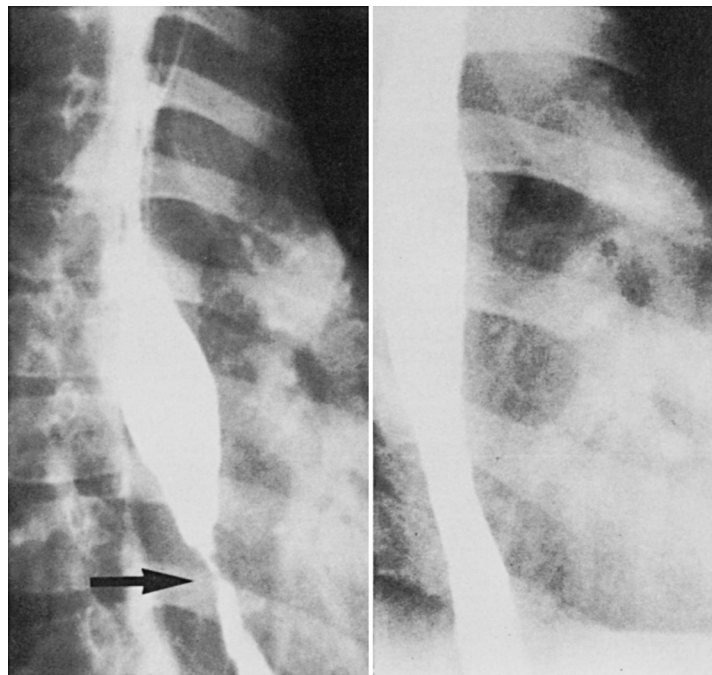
Esophageal stricture. Radiograph of a peptic esophageal stricture (*arrow*) before and after treatment with dilations.
